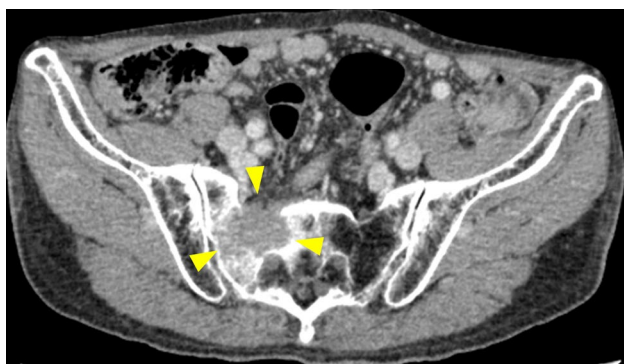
Computed tomography showing osteolysis in the right sacrum
